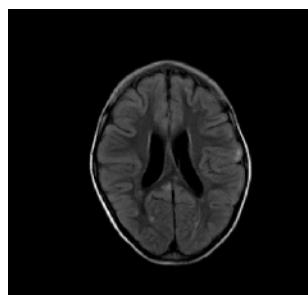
MRI FLAIR showing multiple small cerebral hyperintensities, suggestive of DAI grade 1.
